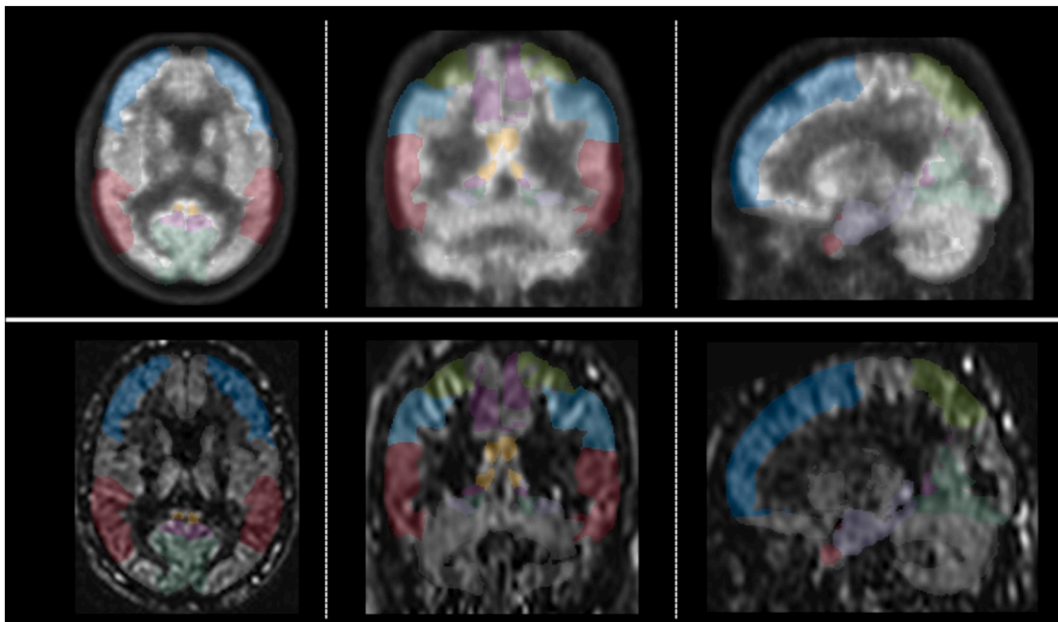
Axial, coronal and sagittal view of a¹⁸F-FDG PET (upper panel) and pCASL (lower panel) normalized images with selected ROIs (left and right) superimposed. Posterior Cingulum (yellow), Occipital Cortex (dark green), Lateral Temporal Cortex (red), Mesial Temporal Cortex (lilac), Precuneus (violet), Lateral Prefrontal Cortex (blue), Inferior (cyan) and Superior Parietal Cortex (light green) are considered.
